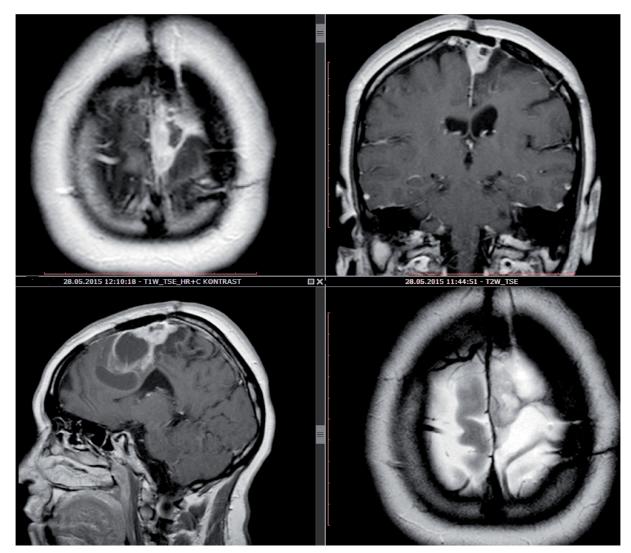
Pre-operative MRI before the third intracranial tumor resection showing both the cystic anterior and posterior solid parts of the recurrent tumor.
